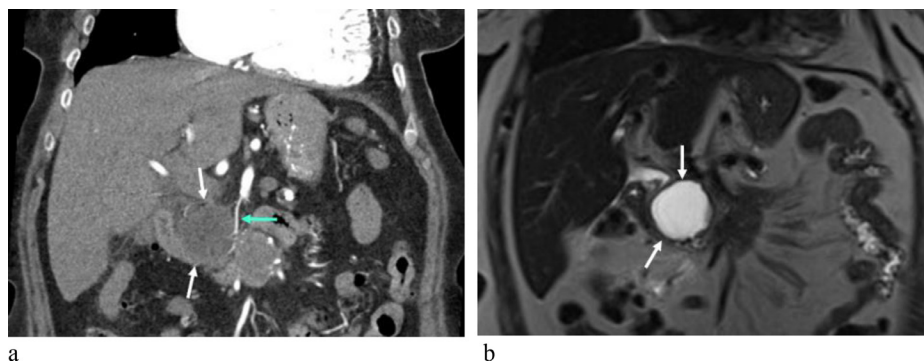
Contrast enhanced CT of the abdomen (a) obtained during admission better visualizes the cyst (white arrows) with an adjacent vessel branching from the SMA (green arrow). MRCP (b) obtained following the CT demonstrates a simple cyst most consistent with a pancreatic pseudocyst. No hemorrhage was noted on the CT or MRCP.
